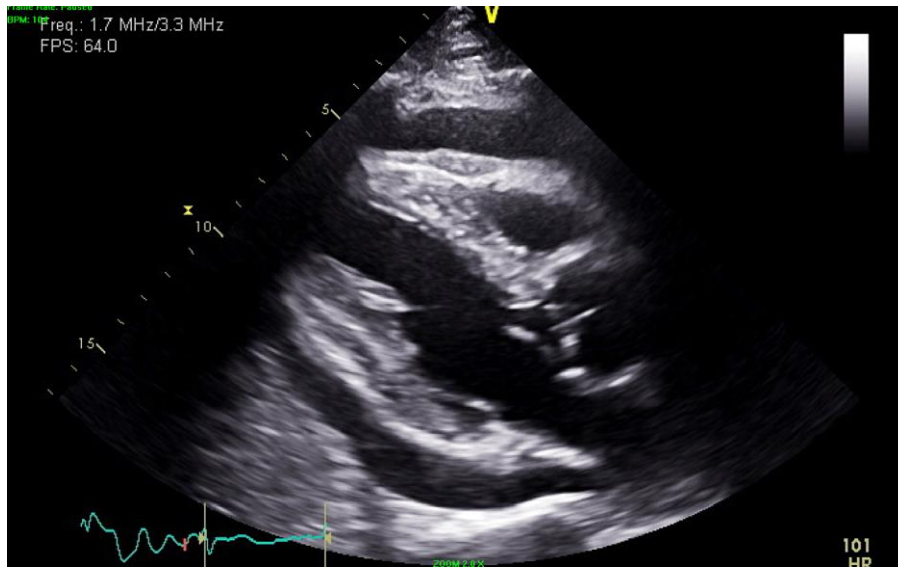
Parasternal long-axis view of pericardial effusion on echocardiogram.
